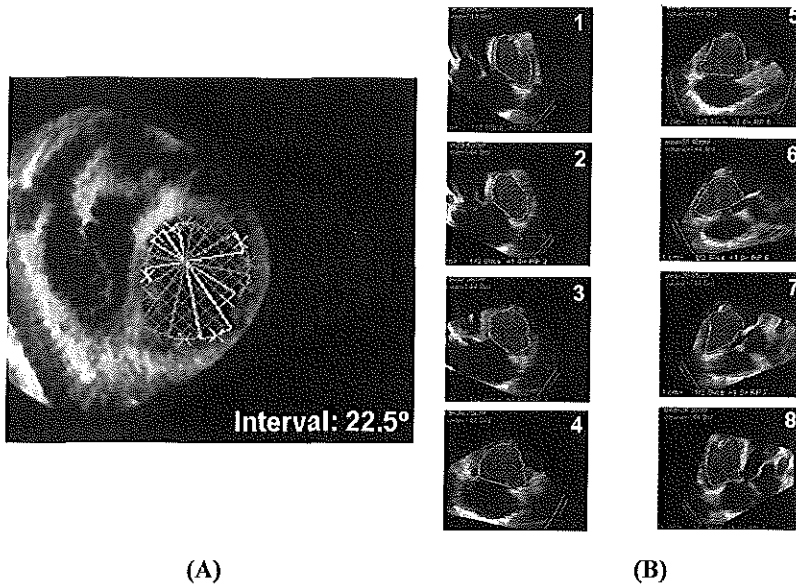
This figure shows the principle of right ventricular volume measurements using the omniplane method. From the three-dimensional echocardiographic data set the reference image is selected with the best right ventricular long axis at 4-chamber view. Around the vertical right ventricular central axis of the reference image, the system gives 8 long axis view at 22.5° of rotational intervals. Panel A shows the segmentation of right ventricular reference cross section around its central axis, to give rise to the 8 long axis views (panel B). Right ventricular volume is calculated by manual endocardial tracing of the 8 right ventricular long axis views at end-diastole and end-systole (panel B).
